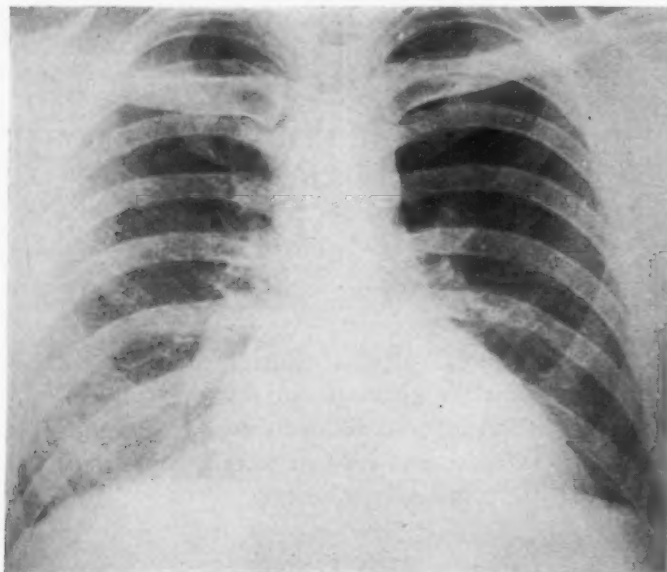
Chest roentgenogram on day preceding second hospital admission shows increase in cardiac silhouette.
